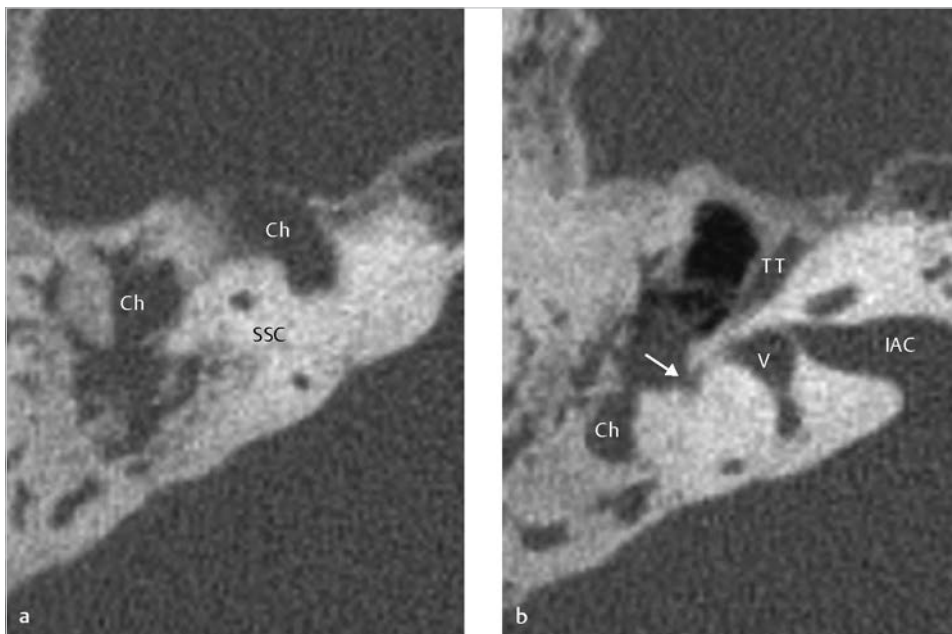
The axial CT shows medial extension of cholesteatoma surpassing the superior semicircular canal. Even though the tympanic cavity is pneumatized to some extent, a small labyrinthine fistula is identified in the lateral semicircular canal (*arrow*). The head of the malleus and the whole incus are missing in the attic. Ch, cholesteatoma; IAC, internal auditory canal; SSC, superior semicircular canal; TT, tensor tympani; V, vestibule.
